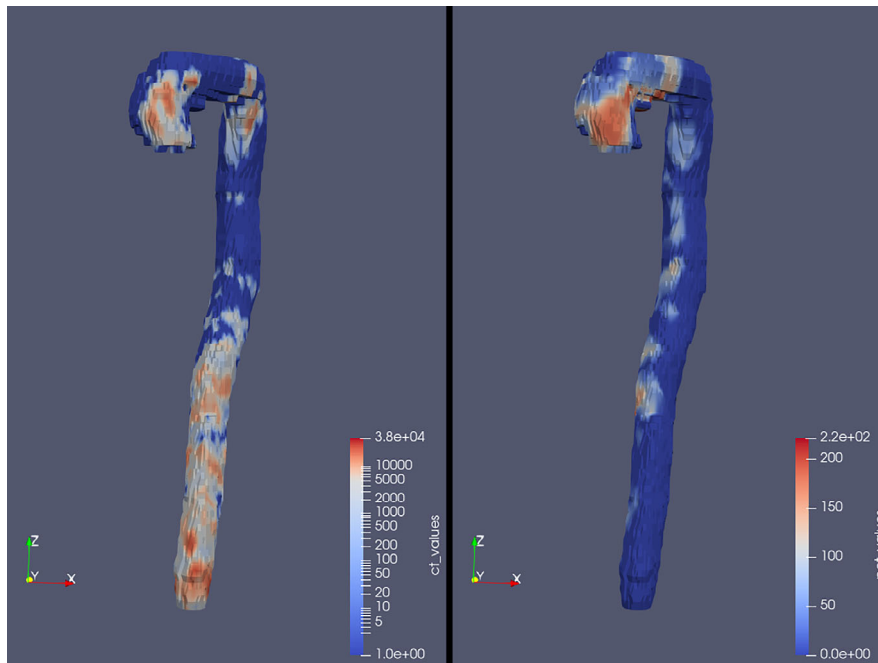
An example of two 2D surface meshes with the CT calcium distribution (left; in log scale) and the 2-[^{18}F]FDG uptake hotspot distribution (right). A video of these surface meshes can be found in the supplementary (Video S-1). HTML files can be found on the GitHub page (<https://github.com/UMCG-CVI/SEQUOIA>) to view these meshes in the interactive ParaView Glance tool.
